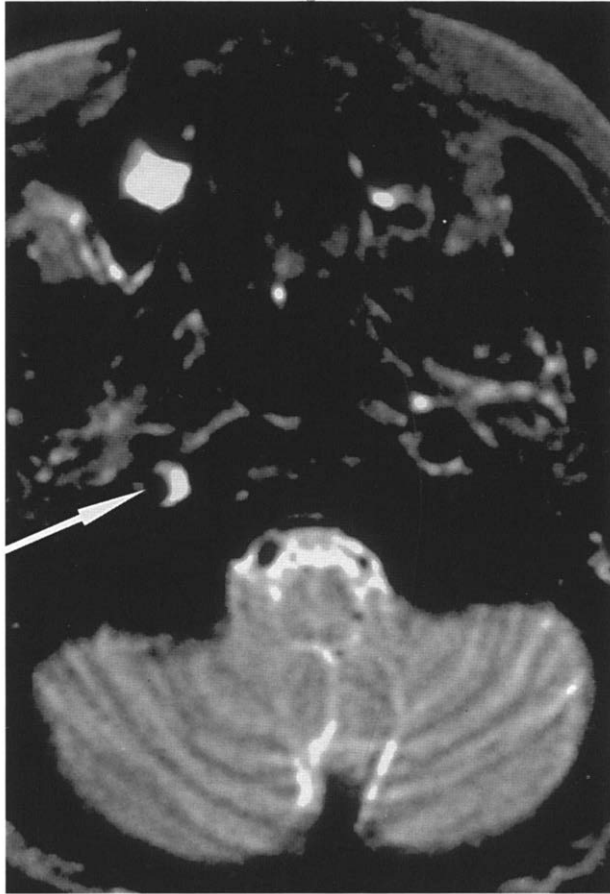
Axial T<sub>2</sub>-weighted magnetic resonance imaging (MRI) image of brain, showing small crescent of abnormal signal in distal right internal carotid artery (arrow) consistent with arterial dissection.
